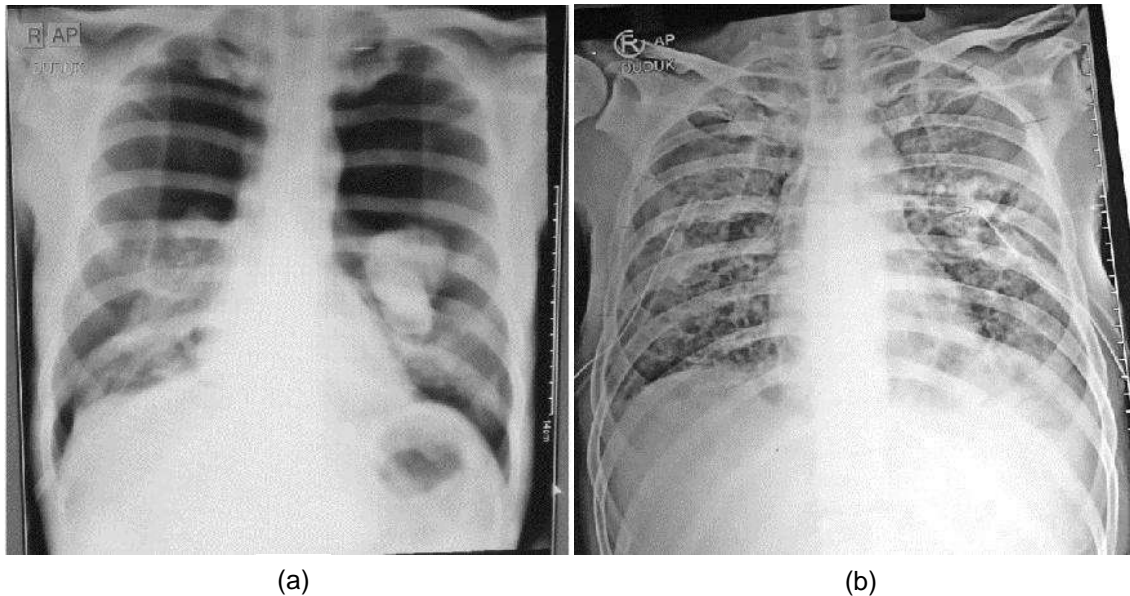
Chest X-Ray taken on (a) admission, radiological examination at the first time the patient went to the referral hospital, and (b) the fifth day, evaluation after IPC chest tube insertion and continuous suction
